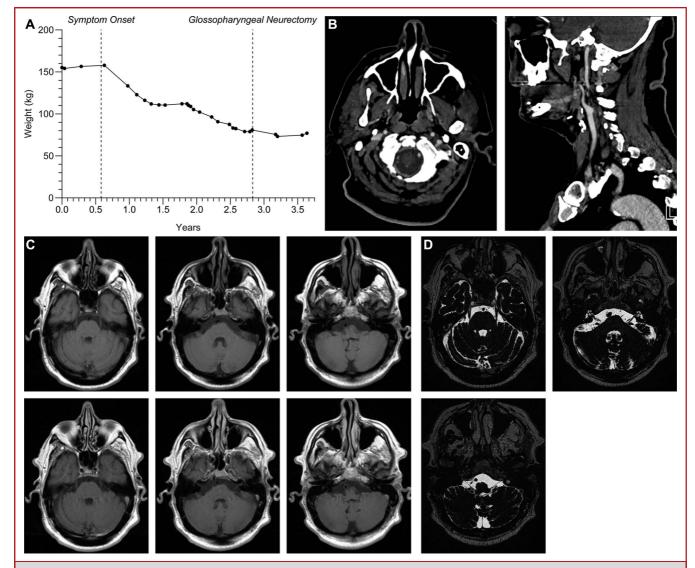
A, Precipitous weight loss depicted in relation to symptom onset. B, Computed tomography with contrast showing absence of recurrent malignancy. C, T1-weighted MRI with/without contrast showing no neoplastic lesion or contrast enhancement of the trigeminal, facial/vestibulocochlear, and glossopharyngeal nerves. D, Constructive interference in steady state MRI showing no distortion or compression of the trigeminal, facial/vestibulocochlear, and glossopharyngeal nerves.
